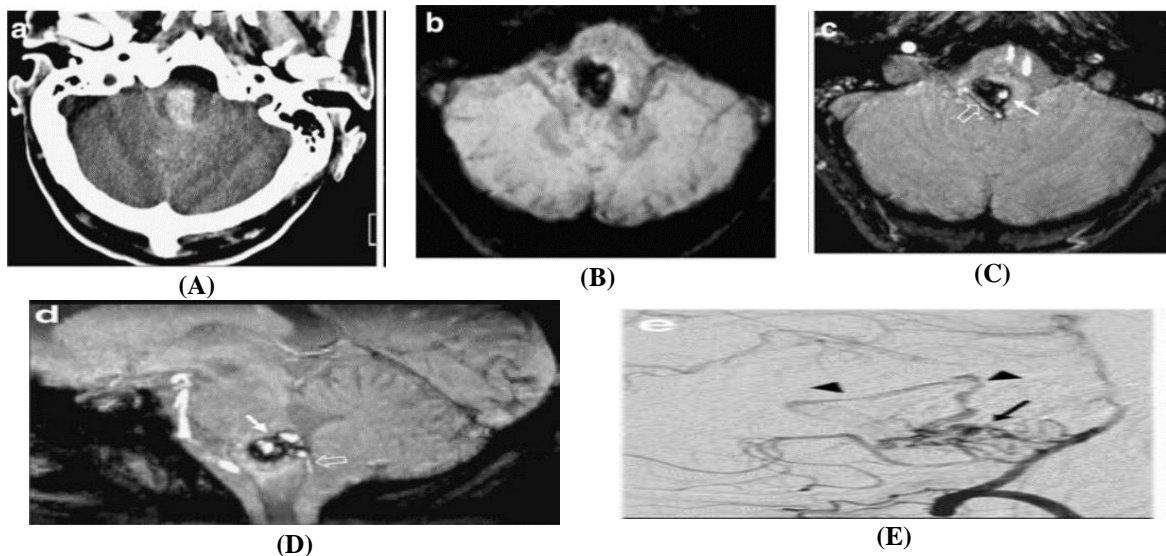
a) CT shows an acute hemorrhagic lesion located in the medulla oblongata. b The SWI minIP image clearly depicts the brainstem hemorrhage, which is markedly hypointense. c, d SWI, axial and reformatted sagittal images, processed with a maximum intensity projection algorithm (MIP), show flow-related enhancement within the hemorrhagic lesion (arrow) and a hypertrophied right posterior inferior cerebellar artery (PICA; open arrow) which are consistent with a small ruptured brainstem AVM. e Cerebral angiography, selective injection of the right vertebral artery: brainstem AVM (arrow) fed by branches of the right PICA and early venous drainage into a cerebellar vein (arrowheads)
